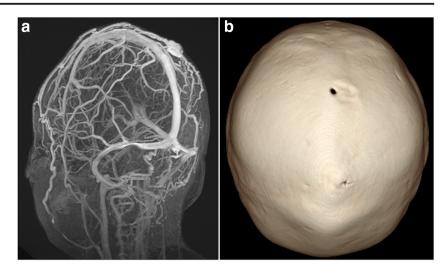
Sinus pericranii associated with paramidline foramen. a Three-dimensional reconstructions from a CT venogram performed in a patient with a midline scalp mass demonstrated a subgaleal venous varix in connection with the cerebral venous system, consistent with a sinus pericranii. The lesion did not appear to constitute a dominant pathway for cerebral venous drainage. b The paramidline foramen was seen on threedimensional reconstructions of bony windows
